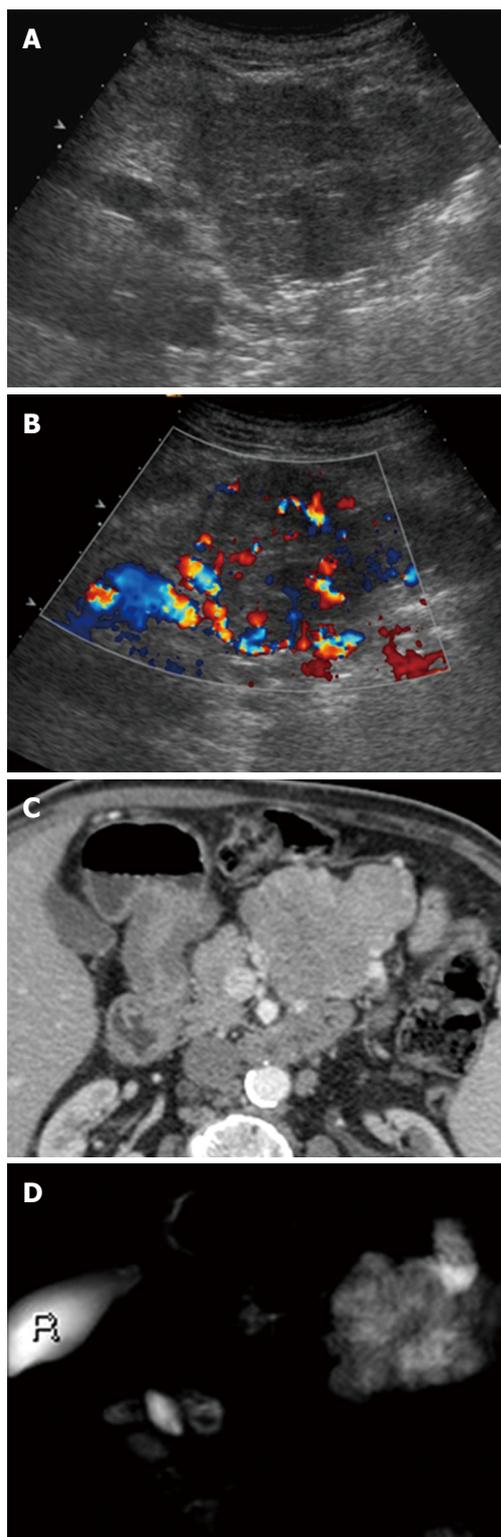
Large pseudosolid serous pancreatic neoplasia. A: With B-mode ultrasound a huge mass is visible appearing solid and inhomogeneously hypoechoic; B: Doppler shows large arterial vessels within the mass; C: With Computed tomography the lesion appears pseudosolid with inhomogeneous slight enhancement; D: Magnetic resonance imaging clearly shows the cystic nature of the mass with microcystic appearance.
